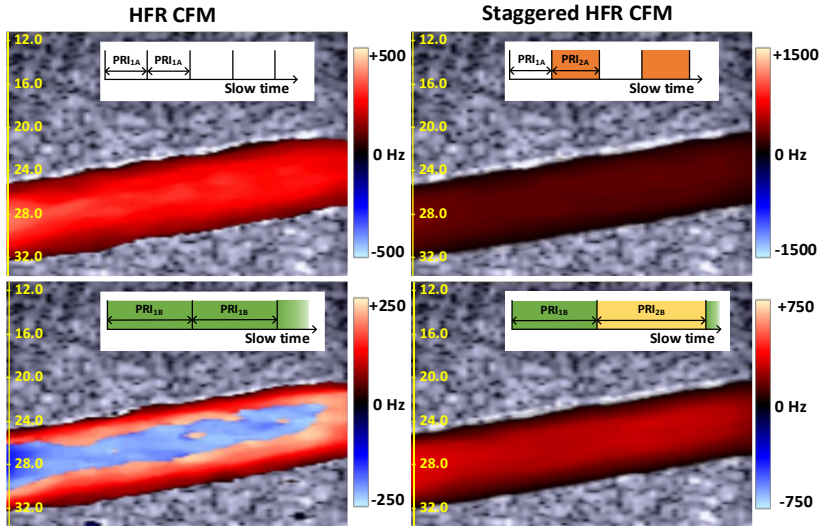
Comparison between (left) conventional and (right) staggered HFR CFM at the peak of the pulsatile flow. At (top) high PRF, both methods yield alias-free results. At (bottom) low PRF, conventional CFM shows aliasing artifacts, while staggered PRF recovers a continuous and unaliased velocity field. Please note that the Doppler color bar differs in each subfigure, as the maximum velocity value is different.
